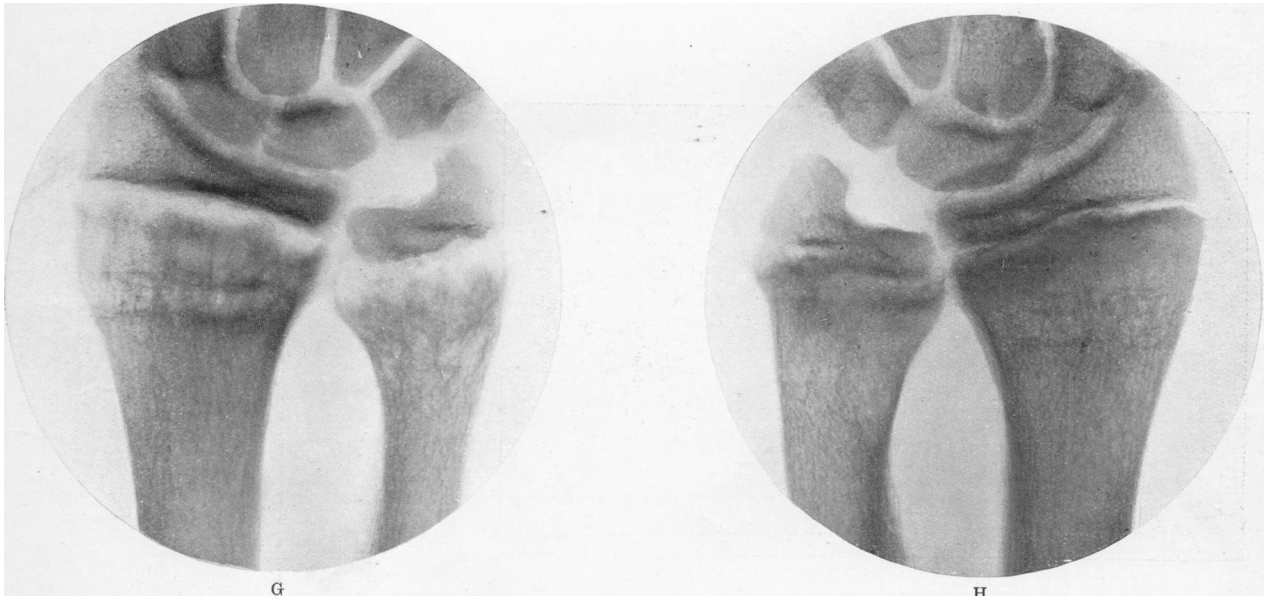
Radiographs of wrist of youth, aged 17 years, with late rickets and osteoporosis. G, as on admission; H, after three months of diet described in text. Note the curative changes both as regards rickets and osteoporosis.
